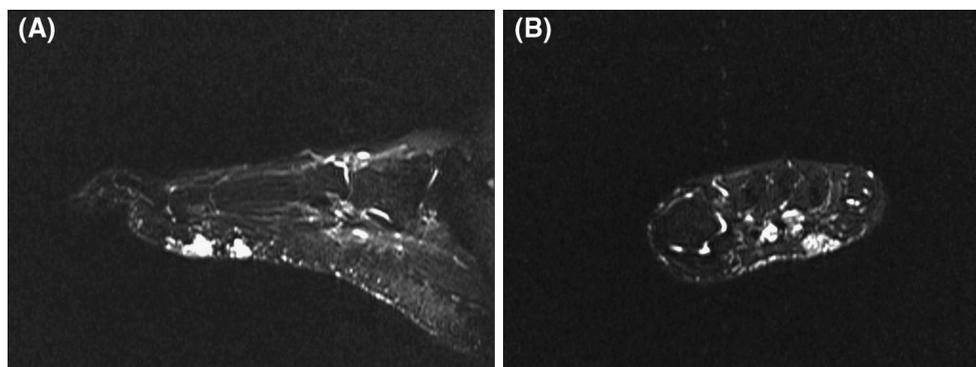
MRI pictures (T2 weighted and fat-suppressed) of the left foot of the patient in Fig. 1. A Transversal and B sagittal images, in which the white discolorations show the superficial VM on the plantar side of the foot
